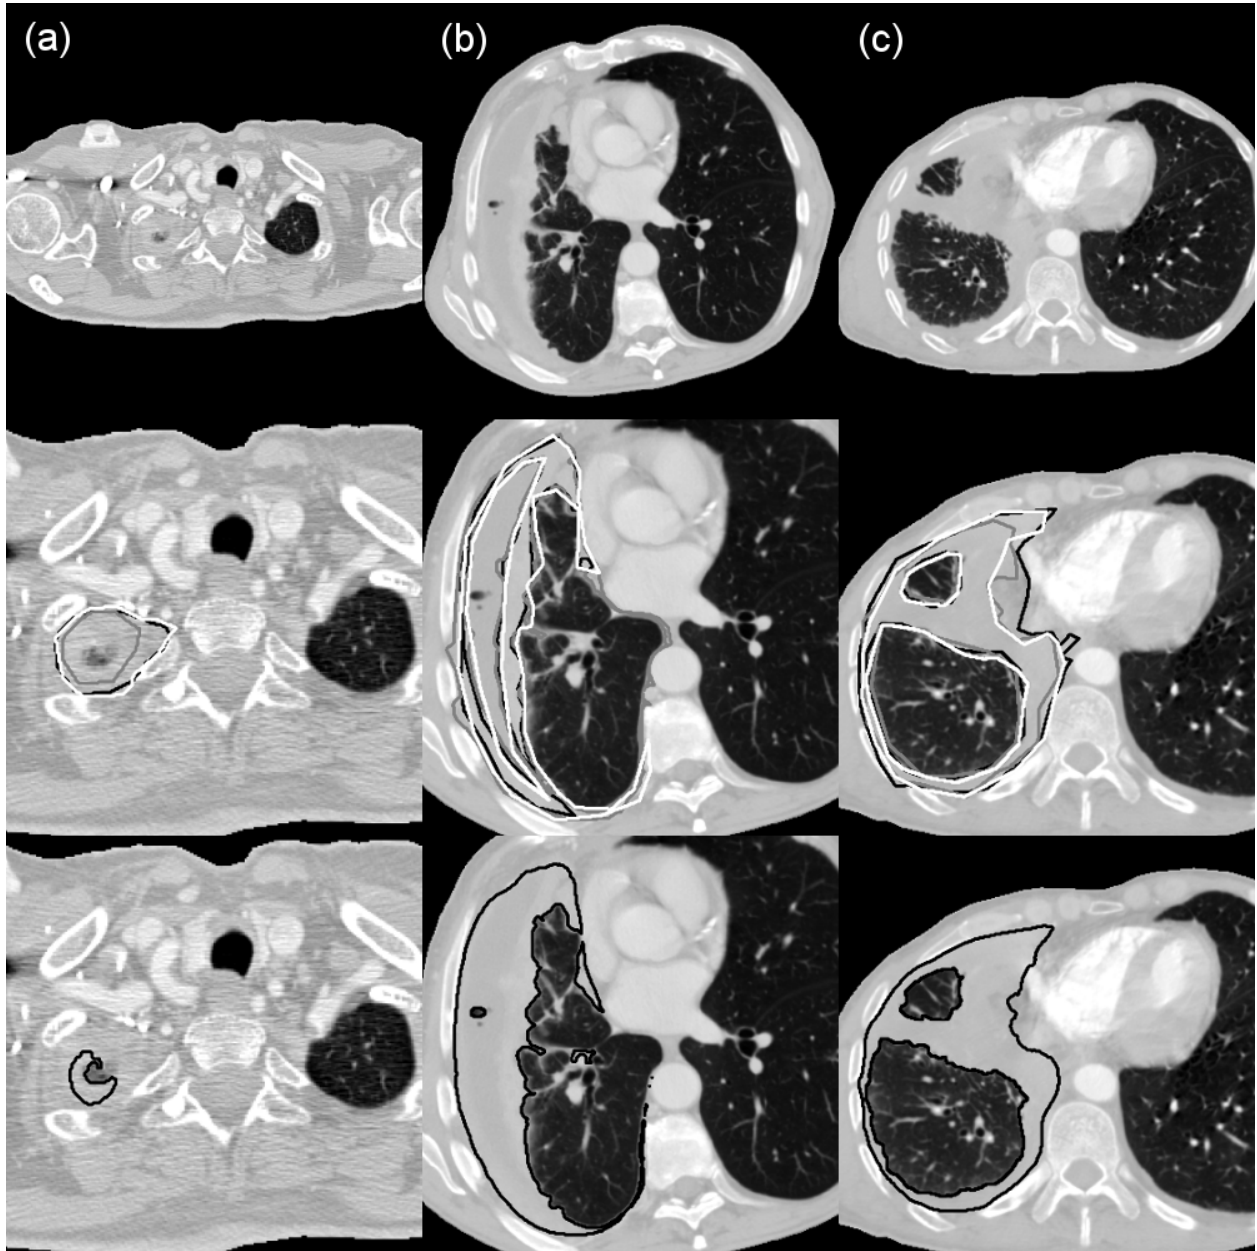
shows the preprocessed CT sections, observer reference segmentations, and deep CNN tumor segmentations for three example CT sections selected at random from the bottom 10th percentile, the interquartile range, and the top 10th percentile of the average DSC value when comparing deep CNN tumor segmentations with observer reference segmentations across both test sets.
